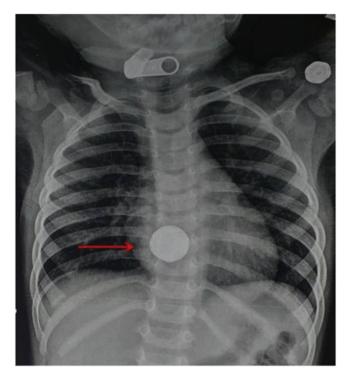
Chest X-ray postero-anterior view showing the classical "double-ring sign".
